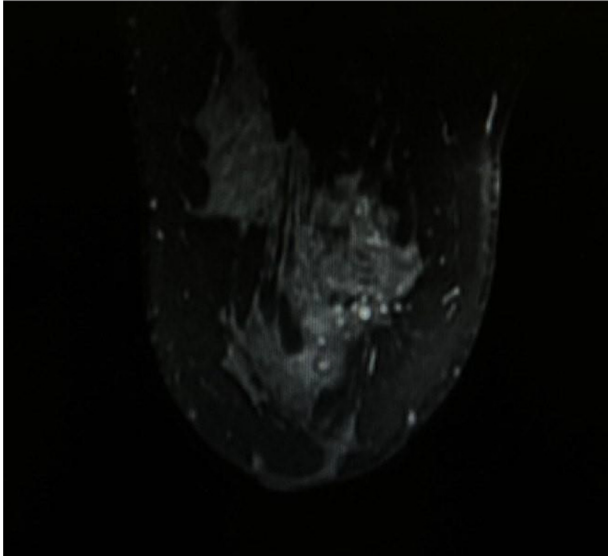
Axial T2W fatsat MRI image of the left breast shows T2 hyperintense cystic areas within the lesion in the upper inner quadrant.
